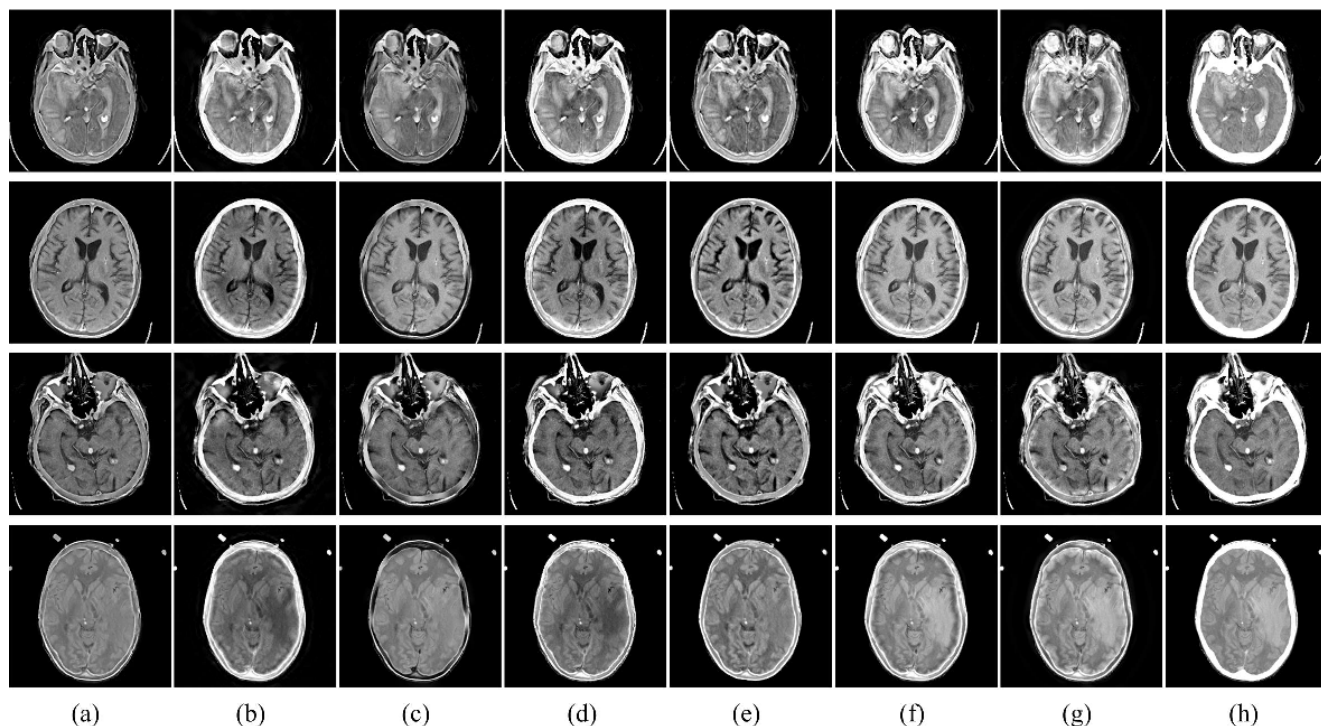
Four experimental results for CT and MR image fusion with eight methods (a) CSR. (b) NSCT-PCNN-SF. (c) GFF. (d) LP-SR. (e) ULAP-MF. (f) NF. (g) NSST-PAPCNN. (h) Proposed.
